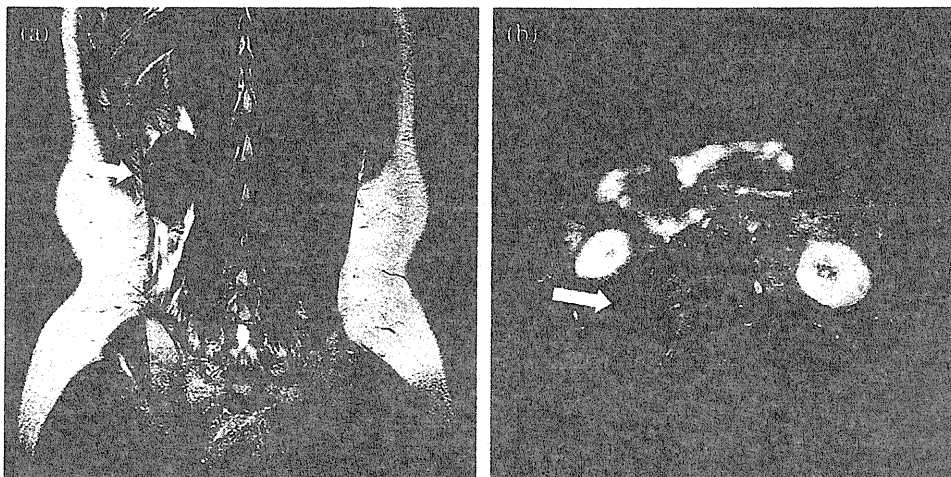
Fifty-six months after carbon ion radiotherapy, T2-weighted image showed obvious reduction of tumor volume (a) and low intensity and contrast-enhanced T1-weighted image showed no enhancement lesion (b).
